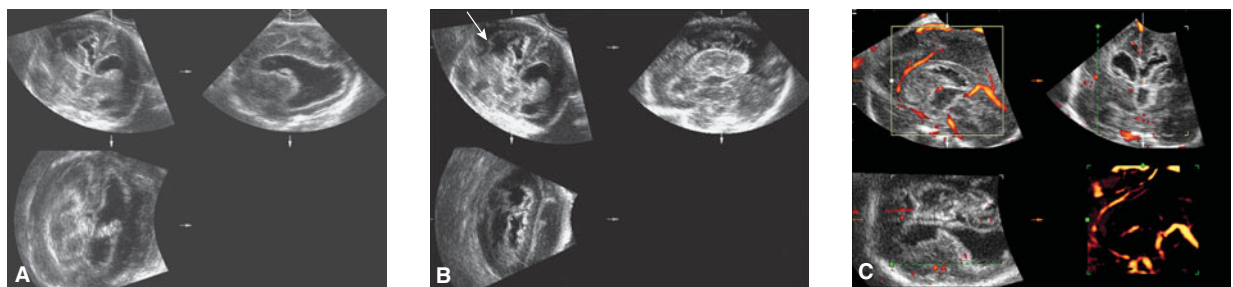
3D orthogonal images of grade IV intraventricular hemorrhage showing parenchymal involvement at 29 postmenstrual weeks. In (A), the head is tilted to the right to allow visualization of the entire ventricle in the oblique section (*upper right*). The axial section is the reconstructed plane. Note the dilation of the lateral ventricles, as well as the brightly echogenic periventricular area. (B) In the coronal section (*upper left*) (*lower left*), involvement of the parenchyma is demonstrated (*arrow*). (C) Power Doppler imaging of the brain. Doppler allows easy evaluation of the pericallosal artery in this fetus with a grade IV intracranial hemorrhage. Note that the areas of intracranial bleeding have no flow.
